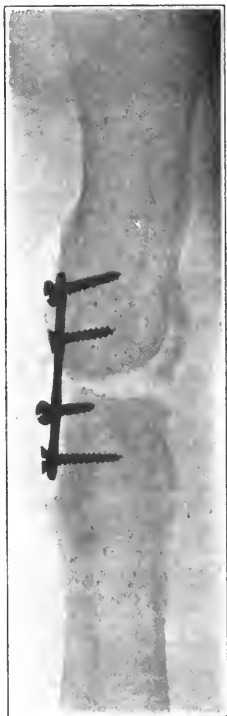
Case 7. X-ray picture showing non-union of fractured humerus with plate in position.
